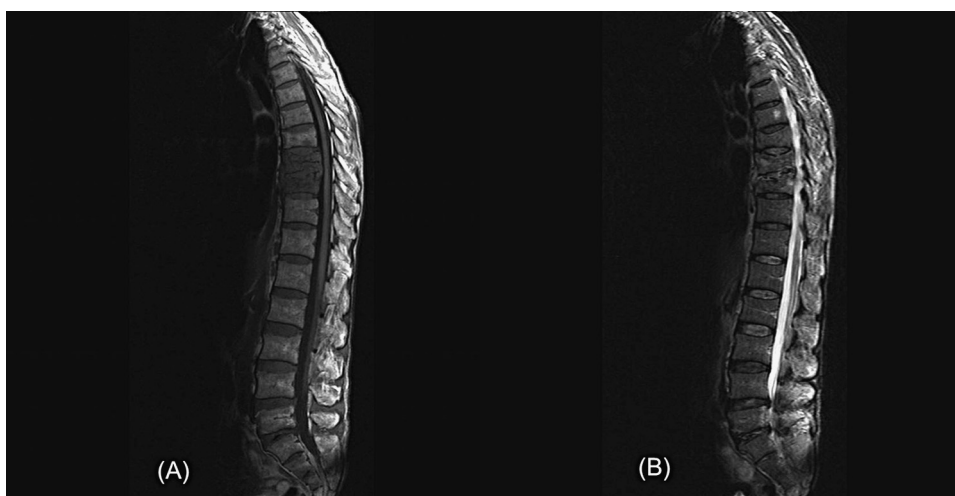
MRI scan of one patient with thoracic spinal tuberculosis showing that the T₉₋₁₀ vertebral bodies are irregularly destroyed. T1WI; the focus shows low signal (A). T2WI; the focus shows uneven high signal (B).
